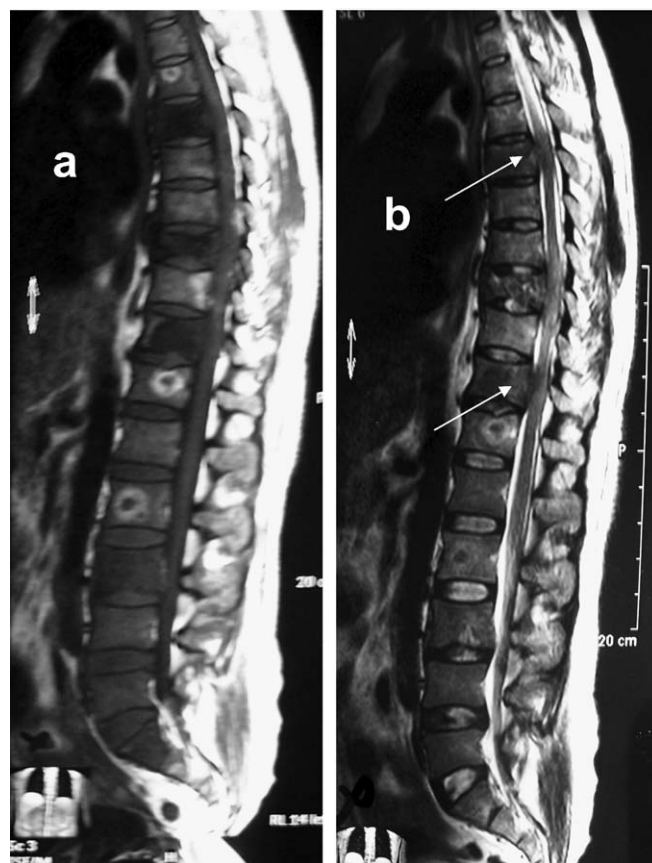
T1 (A) and T2-weighted (B) magnetic resonance images of the lumbar and thoracic spine demonstrating multiple metastatic foci in the dorsal and lumbar vertebrae. There is also 50% height loss of the ninth vertebral body and prominent spinal cord compression. Moreover, spinal cord compression is noted at the 6th and 11th vertebral body levels (arrows).
